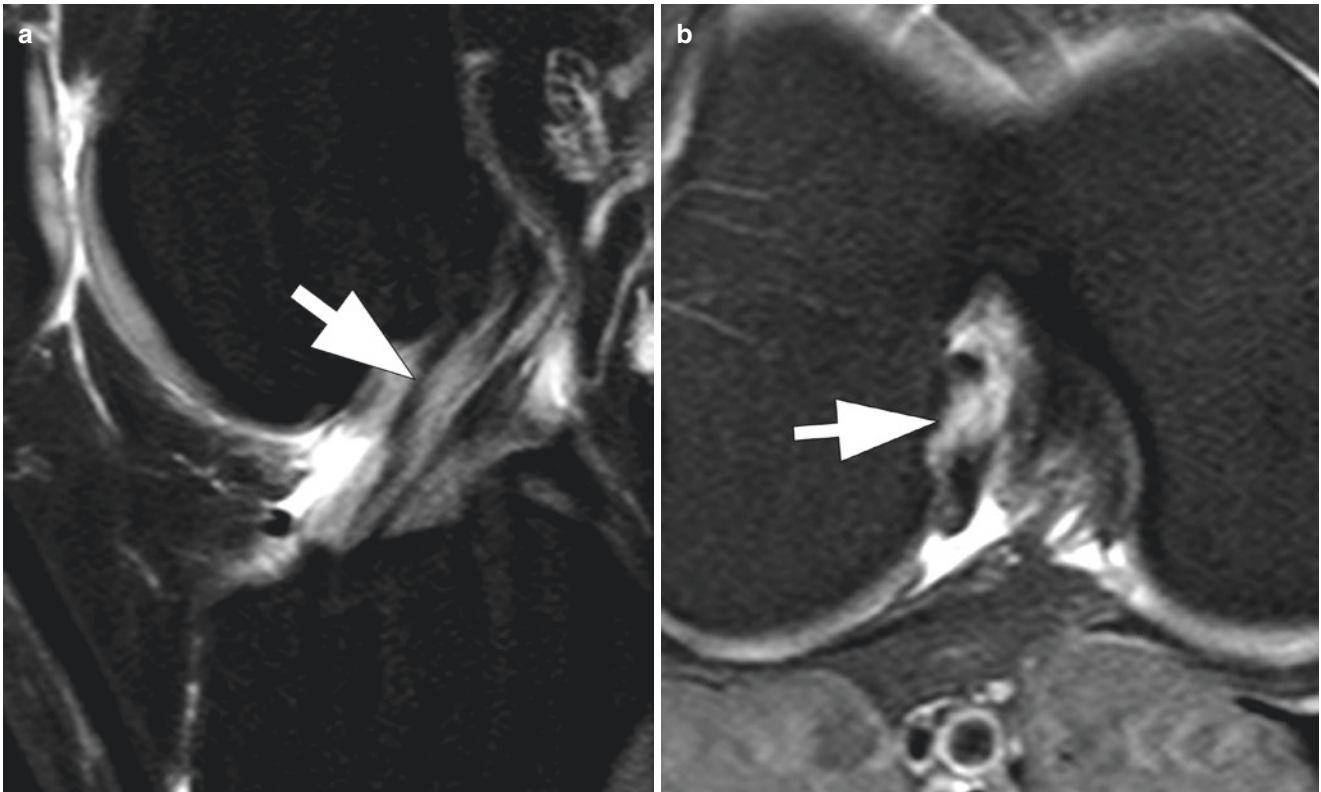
ACL mucoid degeneration. (a) Sagittal and (b) axial T2-weighted images of the knee with fat suppression. There is increased signal within the ACL, with internal ligament striation preserved (arrows)
